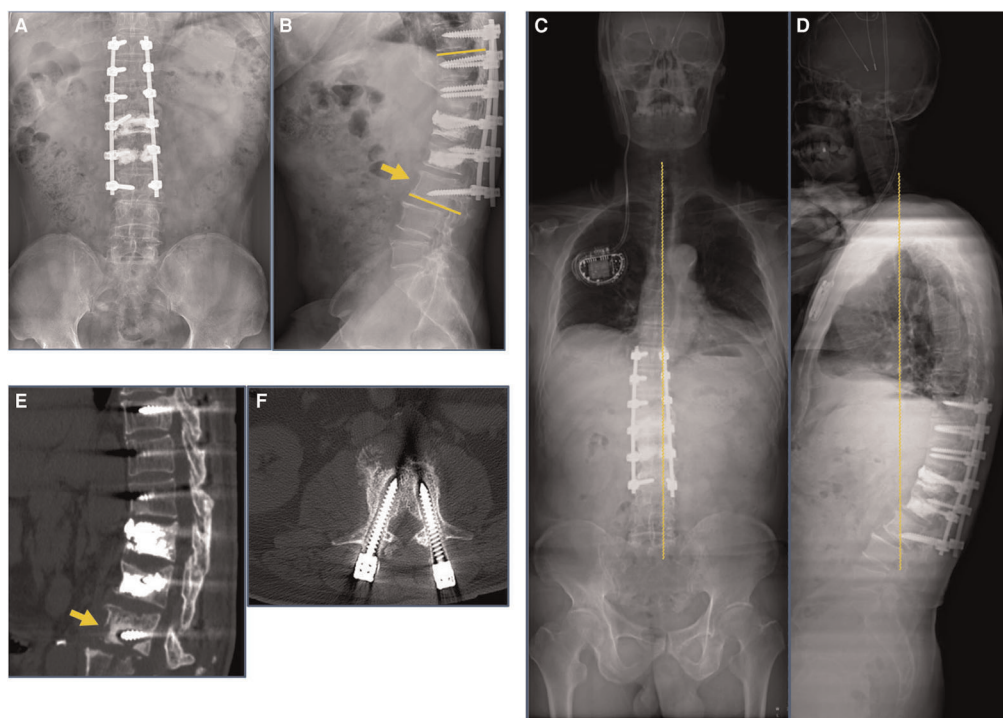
Postoperative 1-month and 3-month imaging findings at our hospital. (A,B) Postoperative 1-month radiograph indicated loosening of the internal fixation screw of the L3 vertebral body (yellow arrow). (C,D) Postoperative 3-month follow-up full-length radiograph of the patient's spine indicated Cobb's angle increased to 26°, failure of internal fixation. (E,F) Postoperative 3-month follow-up CT scan indicated that the L3 vertebral body was loosely fixed internally and the screws had resorbed the surrounding bone (yellow arrow).
